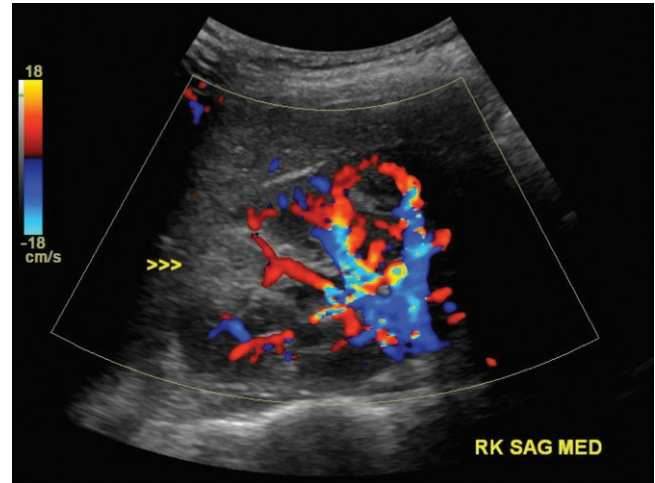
Color Doppler ultrasound of the right kidney demonstrates the echogenic region without color flow seen in the superior pole (arrowheads).
